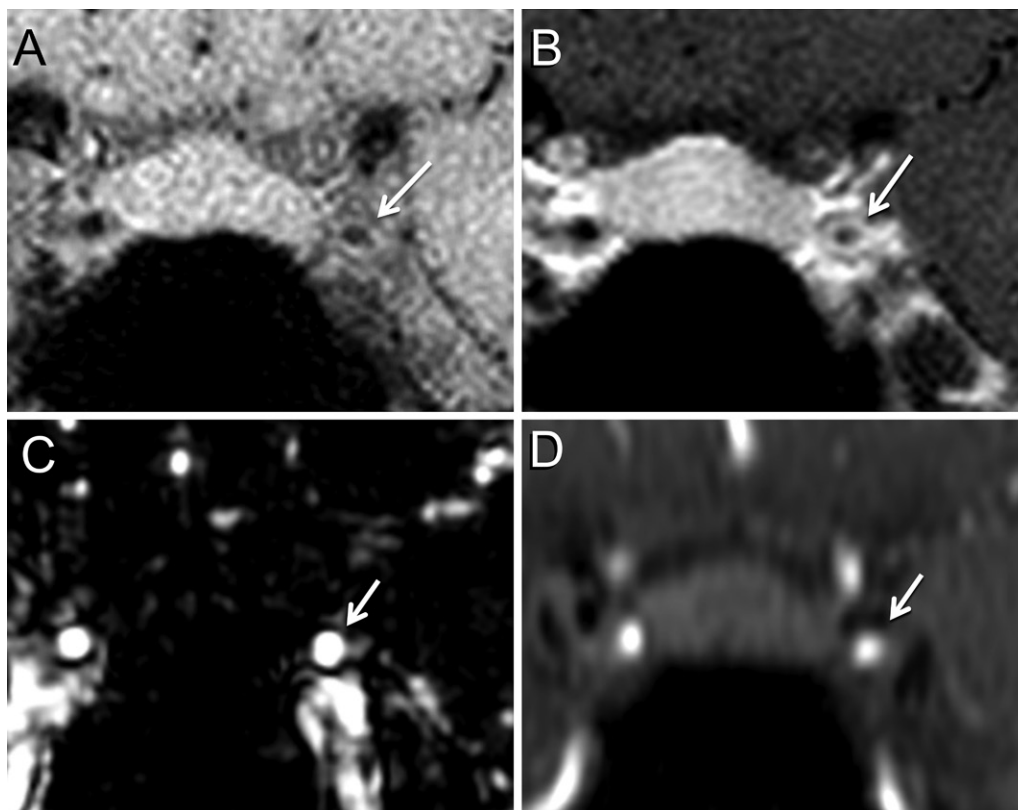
Incomplete blood flow suppression mimicking circumferential wall thickening in a 34-year-old woman with a history of stroke and bilateral distal internal carotid artery (ICA) obstruction. (A, B) Circumferential wall thickening is suggested at the cavernous segment of the left ICA (arrow) on A pre- and B postcontrast coronal vessel wall MRI scans with enhancement on B. (C) Apparent wall thickening and enhancement are artifactual and are confirmed via the widely patent enhanced lumen (arrow) on the arterial phase contrast-enhanced MR angiographic image and related to slow flow from hemodynamic impairment at the ipsilateral carotid terminus. (D) Reconstruction of the time-of-flight MR angiogram at this location shows a patent lumen (arrow), though the caliber is mildly reduced compared with that seen at contrast-enhanced MR angiography because of reduced signal from slow flow at the lumen periphery.
